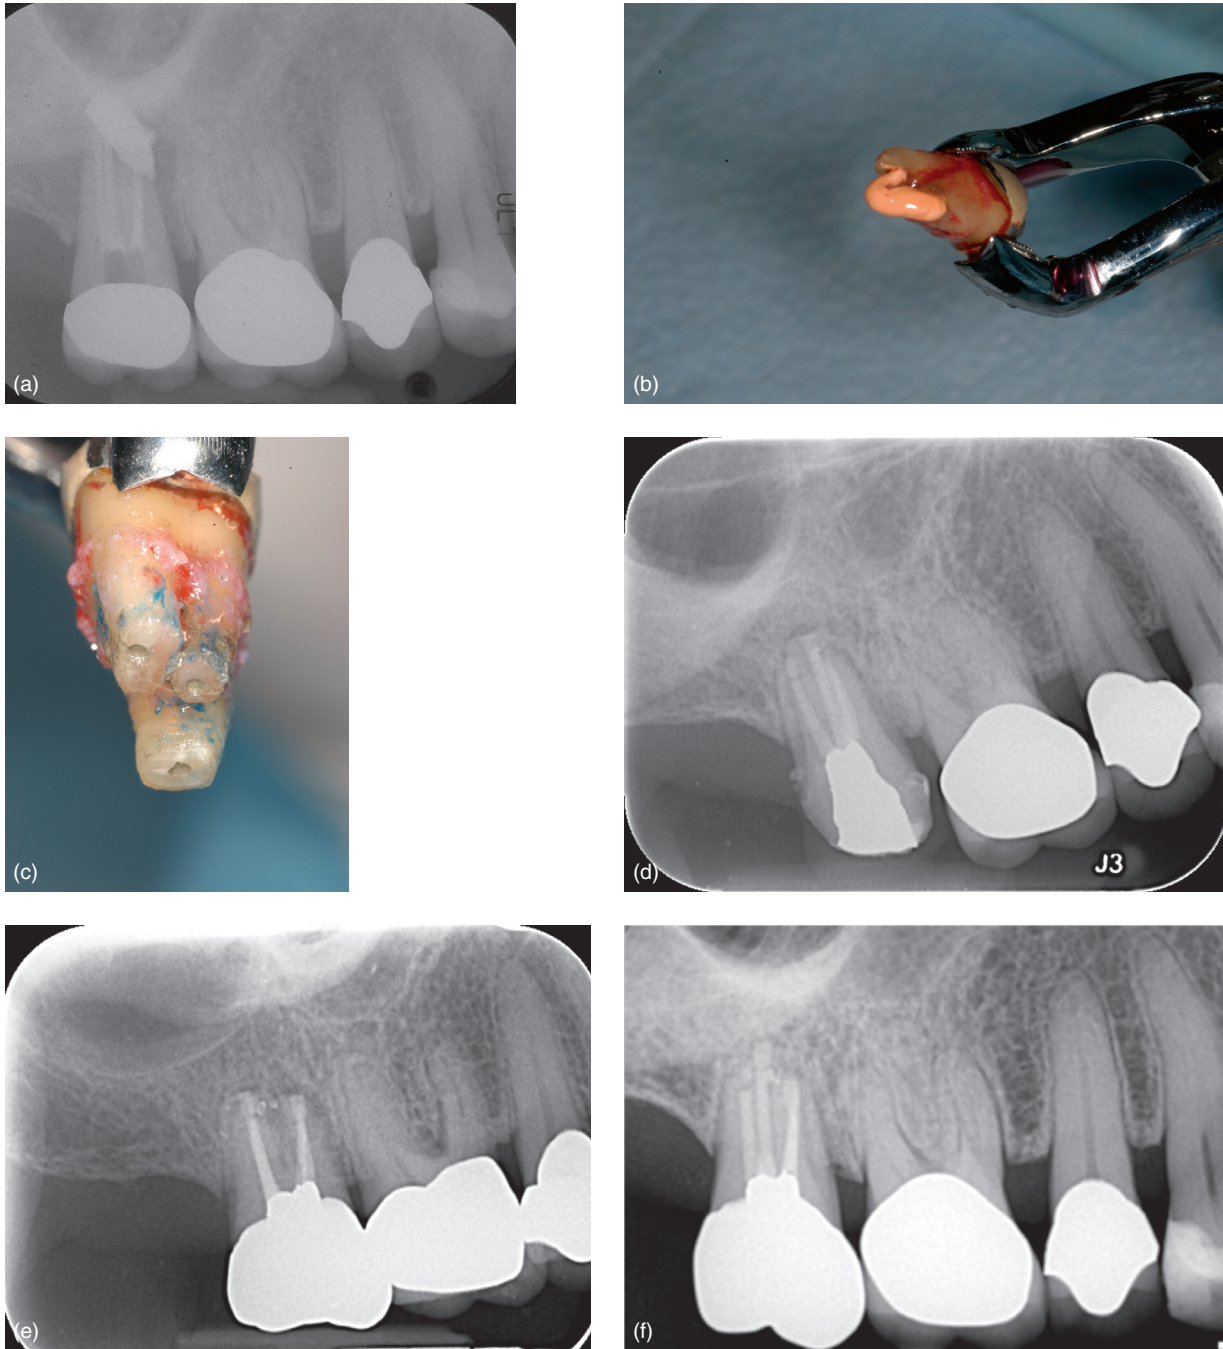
Maxillary right second molar with an overfill of gutta percha, encroaching on the sinus. Retrieval of the excess gutta percha would be impossible with conservative retreatment, and the location of the tooth precluded a surgical approach. (a) Preop radiograph; (b) excess gutta percha came out attached to the tooth; (c) all root ends prepared and filled with gray MTA; (d) postop radiograph; (e) 15 month follow-up showing complete healing; (f) 4 year follow-up. (Courtesy of Dr Mindo Lee.)
